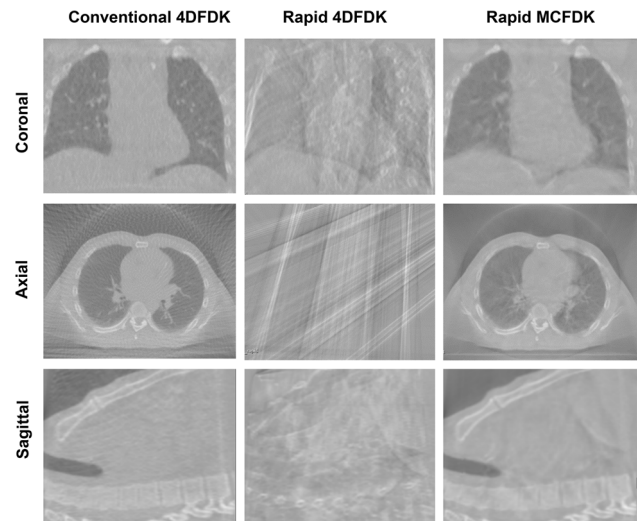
Central slice reconstructions for each 4DCBCT acquisition and reconstruction method considered
